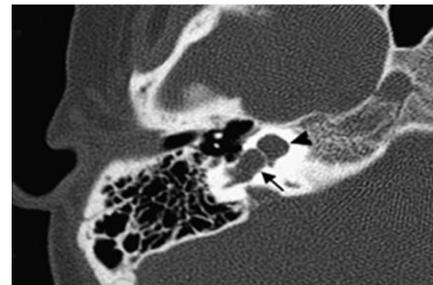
Cochlear hypoplasia. Axial cut CT scan of the left temporal showing cochlea that looks small (arrowhead) and vestibular (arrowhead)
